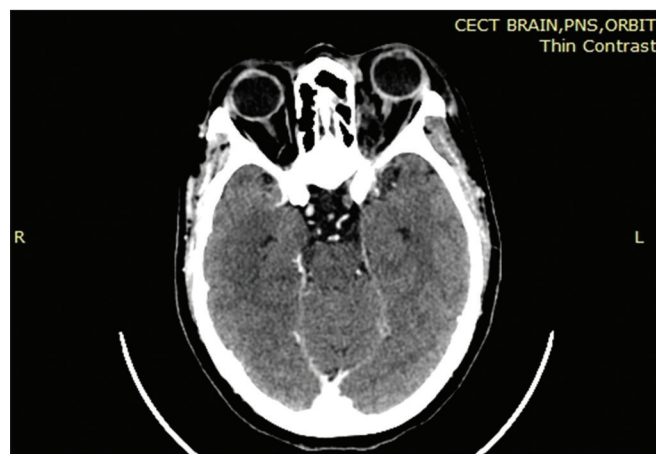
Contrast-enhanced computed tomography showing hypodense filling defect in cavernous segment of the left internal carotid artery suggesting thrombus. Fat stranding is also noted in medial orbital fat on the left side. The left medial rectus appears bulky with soft-tissue thickening
